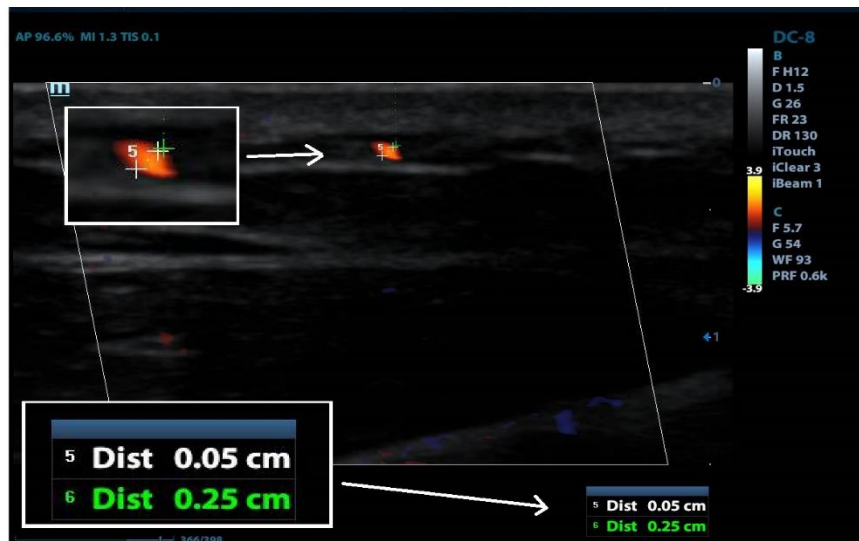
c: Triplex Ultrasonography showed the supraclavicular artery as small as 0.5 mm (zoom in).
